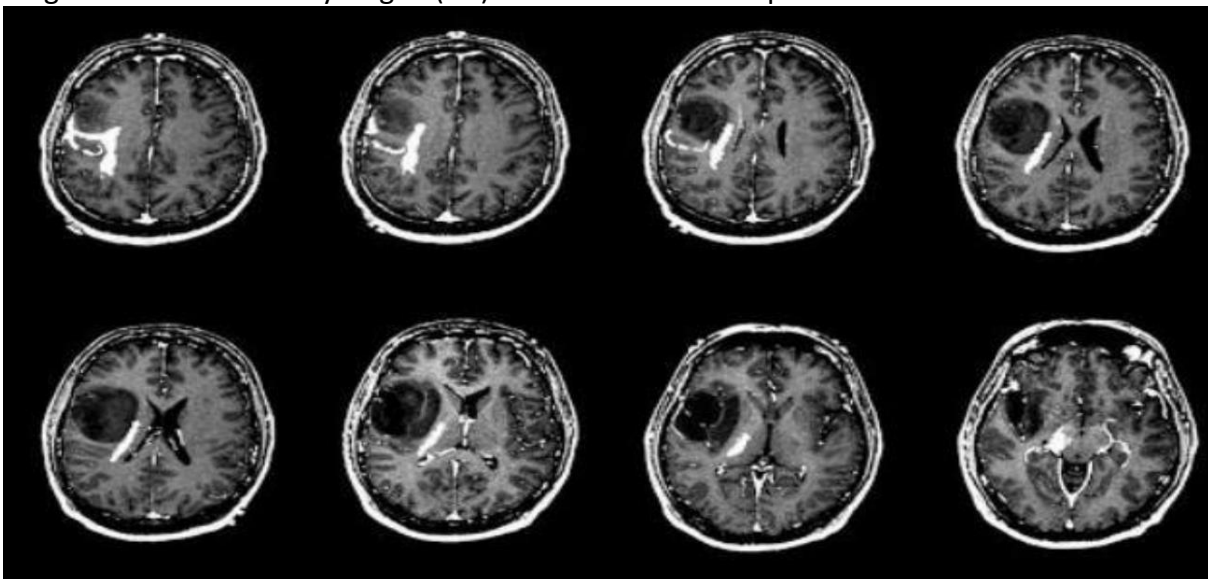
MRI of Human Brain
